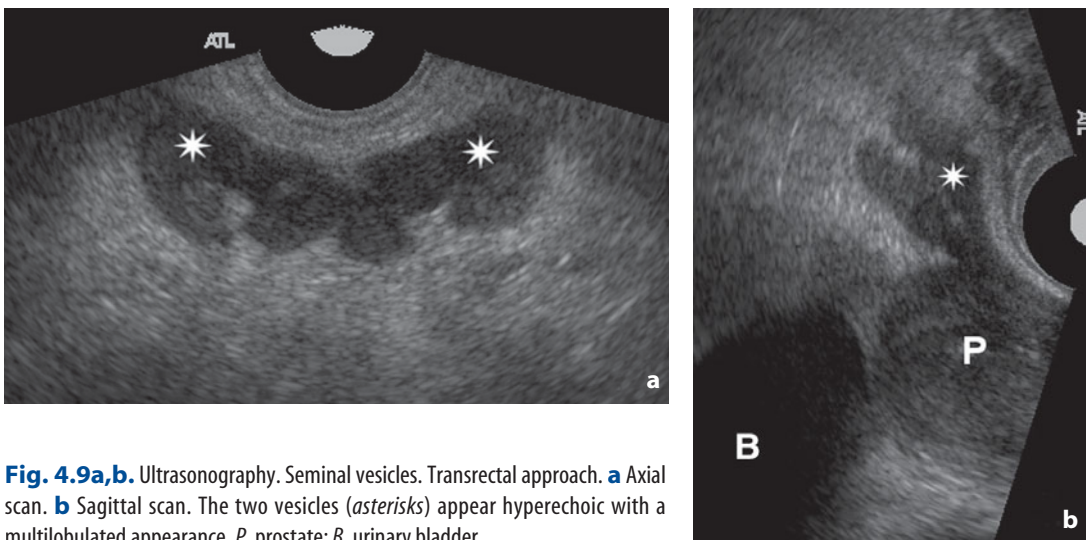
Ultrasonography. Seminal vesicles. Transrectal approach. a Axial scan. b Sagittal scan. The two vesicles (*asterisks*) appear hyperechoic with a multilobulated appearance. *P*, prostate; *B*, urinary bladder
